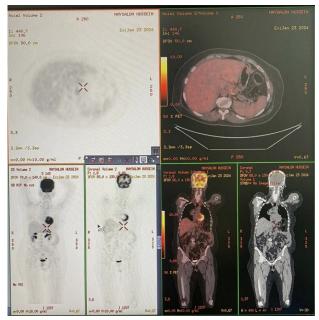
A 48-year-old man with grade II obesity underwent PET-CT. (A) 3D PET; (B) axial tomographic slice at the level of the liver.
